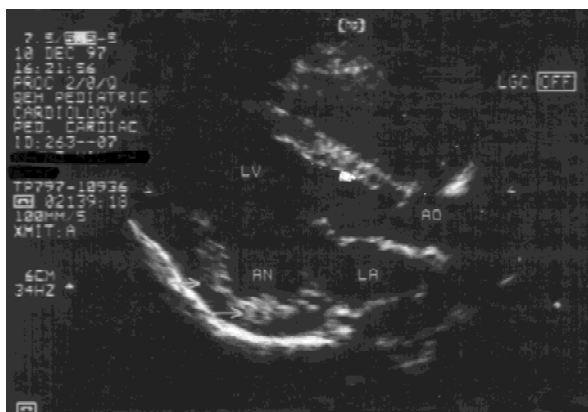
Echocardiography (parasternal long axis view), performed at 6 months of age, showed ventricular aneurysm at posterobasal region of left ventricle. On real time, the aneurysm showed paradoxical expansion during systole. AN, aneurysm; AO, aorta; LA, left atrium; LV, left ventricle.
